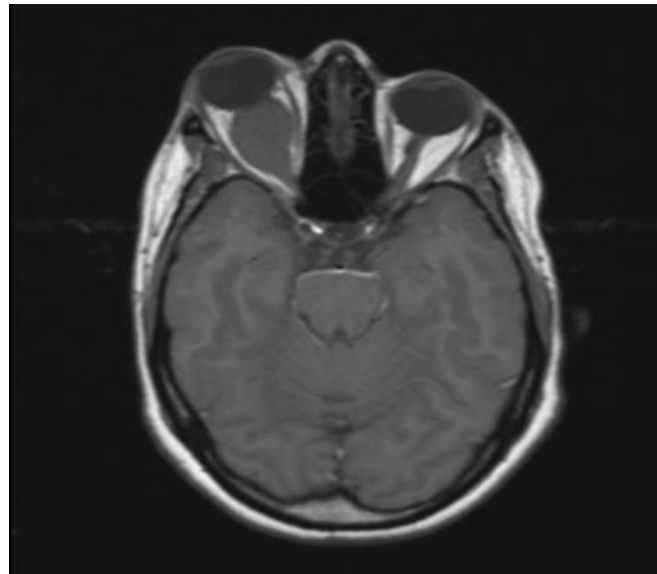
Axial MR image (T1 without fat saturation). An isointense to brain and optic nerve (arrow) lesion which produces exophthalmos. The lesion appears as marked widening along the path of the optic nerve but there is no intracranial extension
